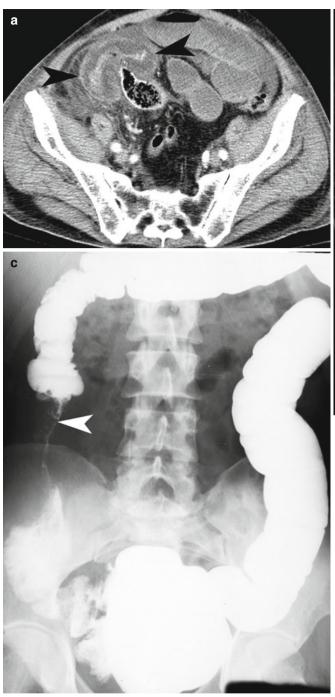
Typhlitis (\mathbf{a}, \mathbf{b}) and ileocecal tuberculosis (\mathbf{c}) . (\mathbf{a}, \mathbf{b}) Axial and coronal CT images of the abdomen in a patient with chronic lymphocytic leukemia demonstrate inflammatory thickening of the cecal wall (*arrowheads*), secondary to typhlitis. (c) Single-contrast barium enema
